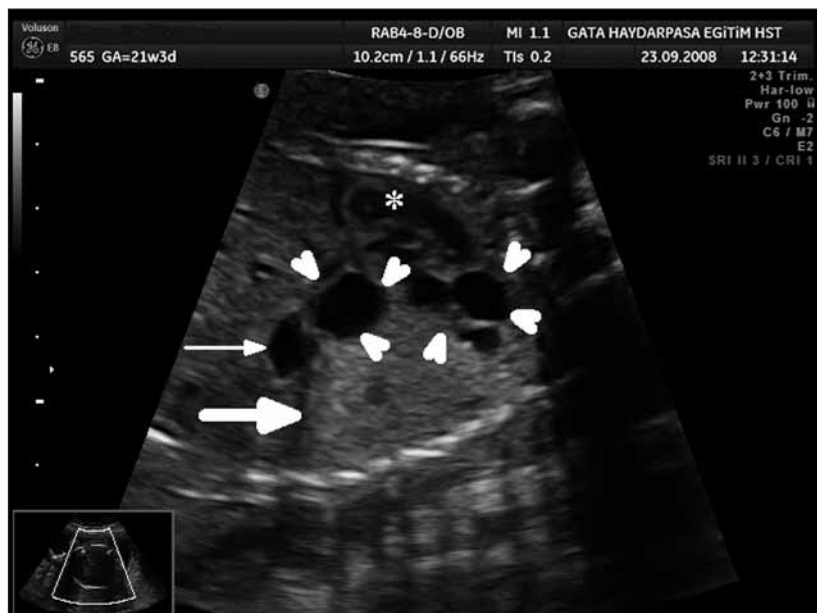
Shape 2. Sagittal ultrasonographic section of thorax and upper abdomen in the fetus with type I congenital cystic adenomatoid malformation, showing intact diaphragm (thick arrow), stomach (thin arrow), cystic lesions (arrowheads) in the left lung and heart (asterix).
